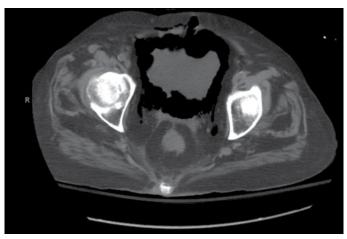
Representative CT scan images demonstrated diffuse air within the bladder wall extension into the space of Retzius and subcutaneous fat.
